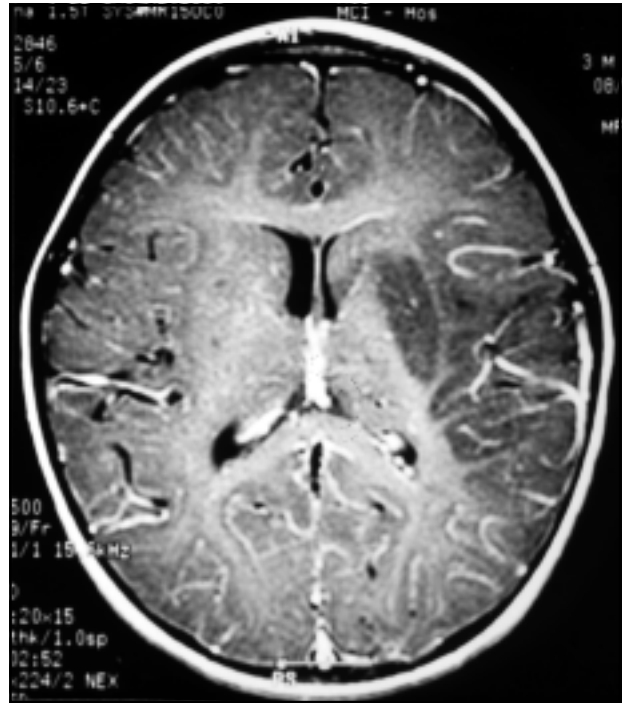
CT. Patient 4 - Left middle cerebral artery territory involved.
